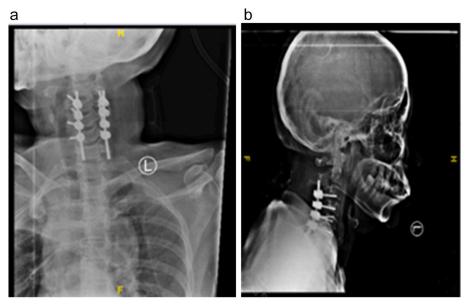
Plain x-ray of the cervical after operation: A. anterior-posterior cervical photo, B. Lateral cervical photo.
